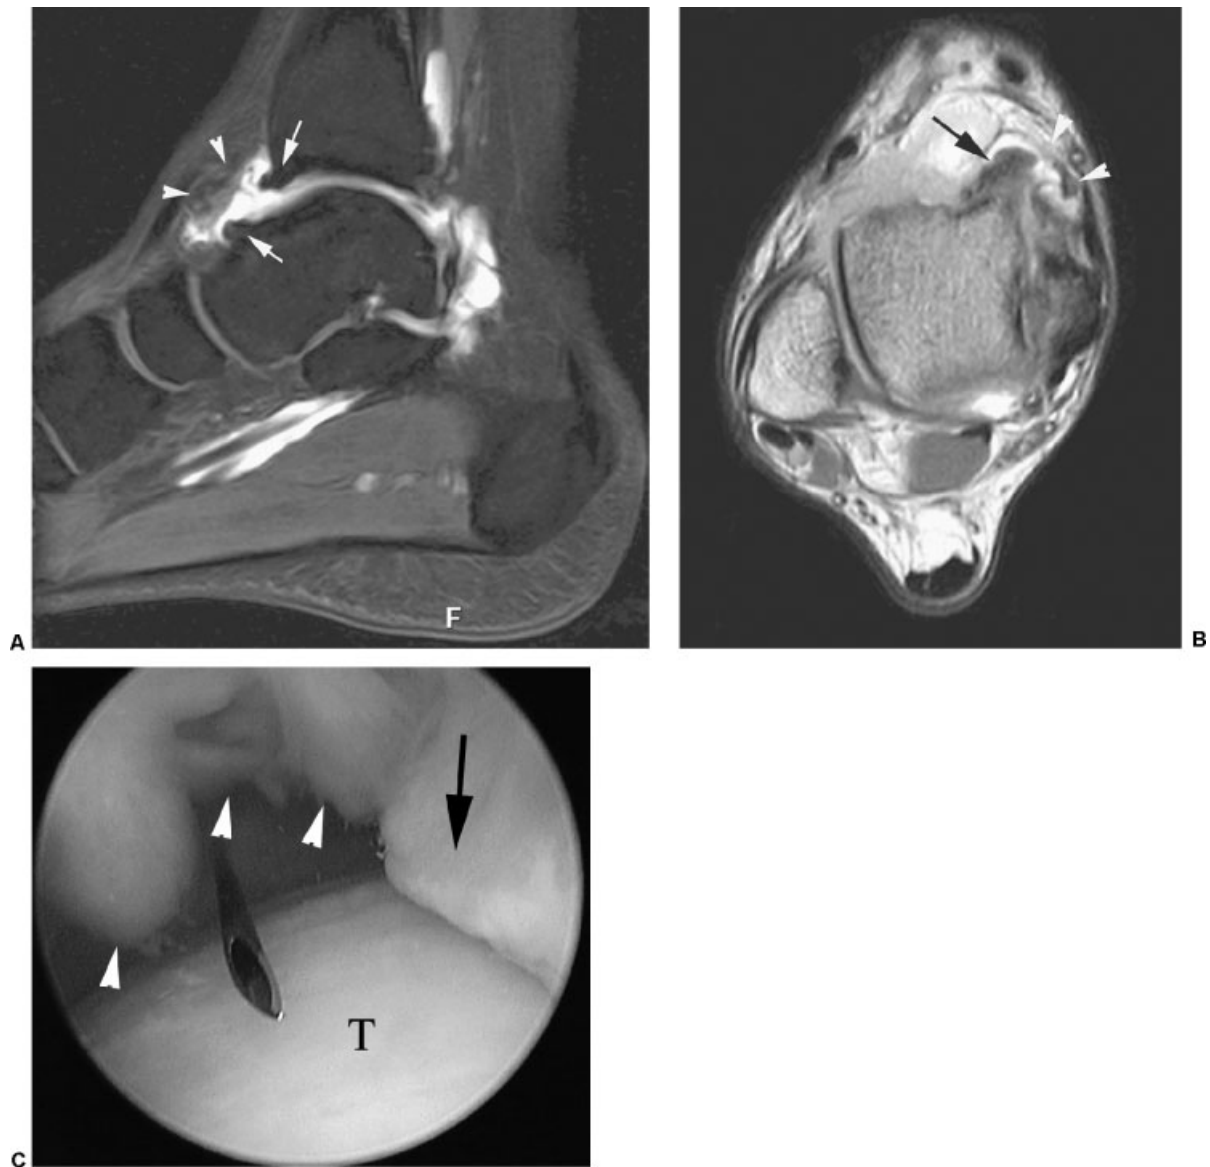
A 28-year-old male professional soccer player with anterior impingement syndrome. (A) Sagittal fat-suppressed T1-weighted spin-echo magnetic resonance (MR) arthrogram of right ankle demonstrate anterior tibial and talar osteophytes ("kissing lesion") (arrows) and an irregular soft tissue mass in the anterior capsular recess (arrowheads). (B) Axial T1-weighted spin-echo MR arthrogram shows anterior talar spur (arrow), with capsular thickening and fibrosis in anterior capsular recess (arrowheads). (C) Arthroscopic image reveals anterior tibial osteophyte (arrow) and anterior capsular recess synovitis (arrowheads). T, talus. Reprinted with permission of Dr. Antonio Cruz, Santander, Spain.
